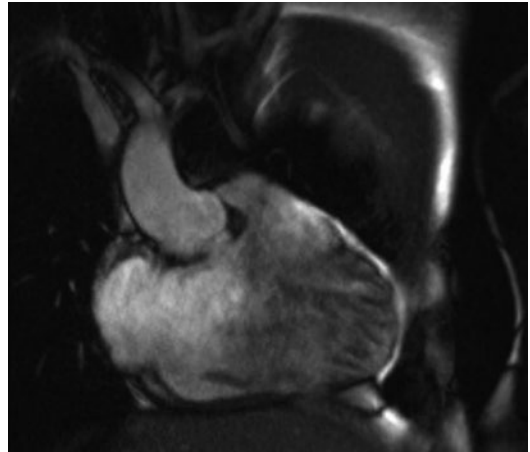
Cardiac MRI showing dilated right ventricle
